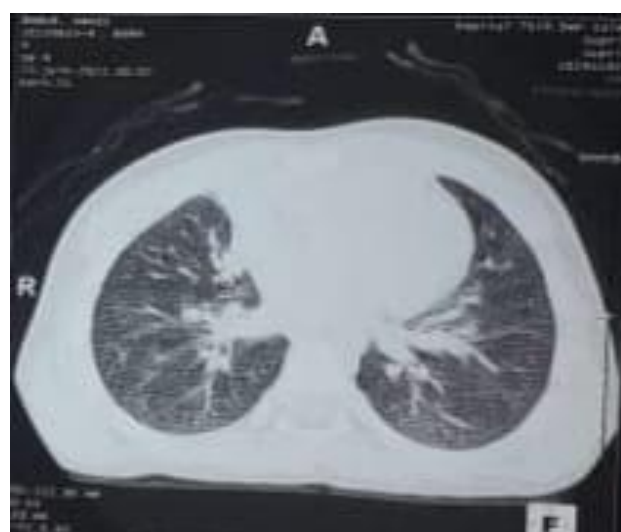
Thoracic CT scan (parenchymal and mediastinal window) showing a mediastinum tumour complex in the right lung extending towards the trachea, thymus and mediastinum dome.
